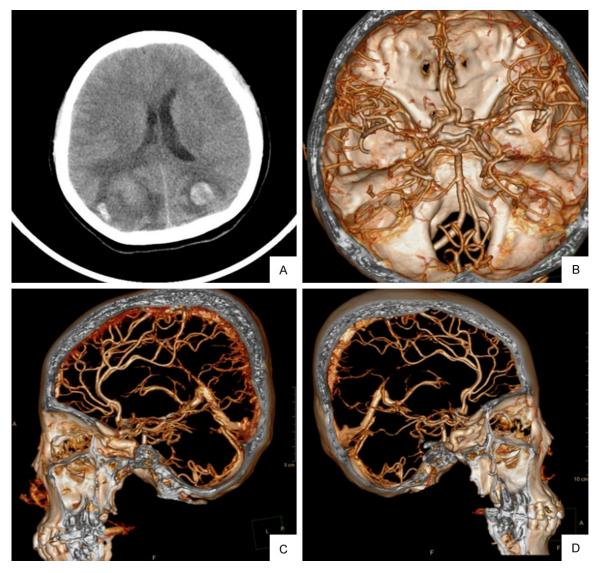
The head CT scan. Her head CT scan indicated cerebral hemorrhage in bilateral parietal lobe and occipital lobe (A). DSA did not find obvious blood vessel fracture (B-D).
